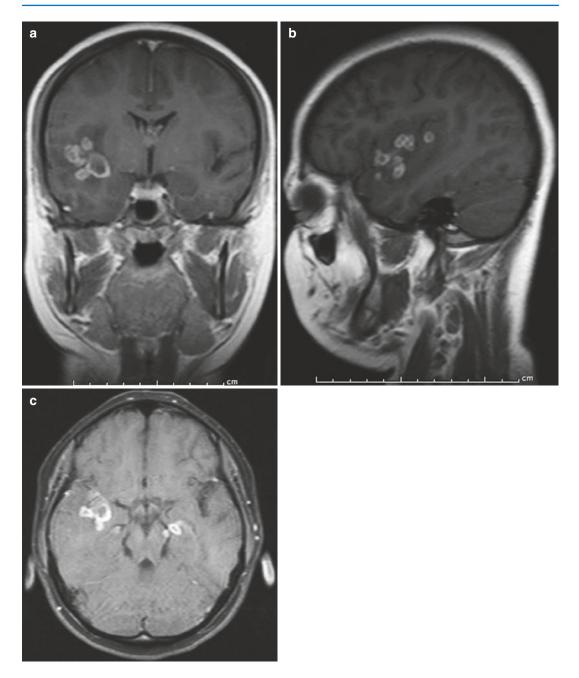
Coronal (a) and sagittal (b) and axial (c) on fat-suppressed contrast-enhanced T1-weighted images show peripheral or ring enhancement multiple tuberculomas on cerebral hemispheres
